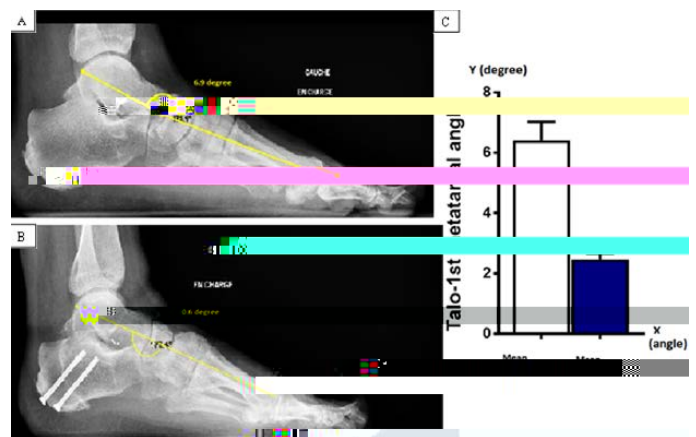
A) Preoperative Tarso-1st Metatarsal Angle Measurement on a Lateral Ankle Plain Radiograph. B) Postoperative Tarso-1st Metatarsal Angle Measurement on a Lateral Ankle Plain Radiograph. C) Results of the Mean Distribution of the Tarso-1st Metatarsal Angle Preoperatively and Postoperatively.
